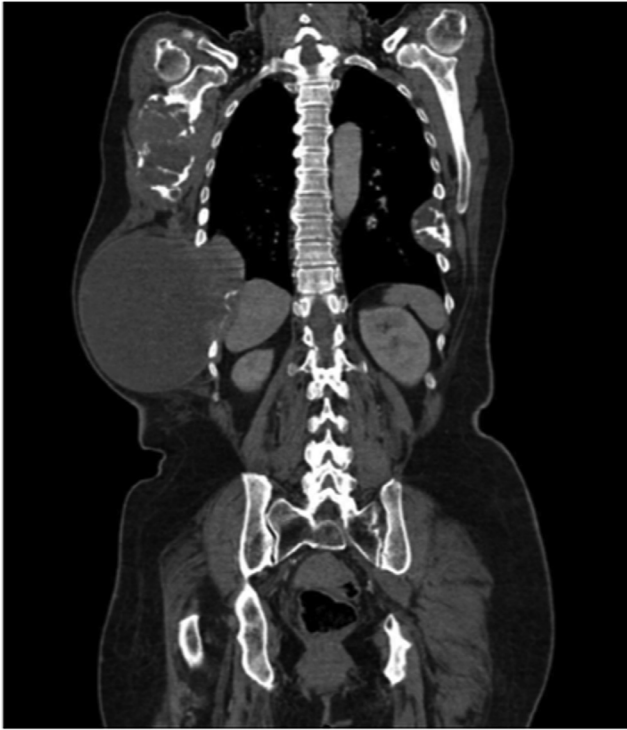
Coronal CT scan showing an increase in size on the right with regression on the left.
